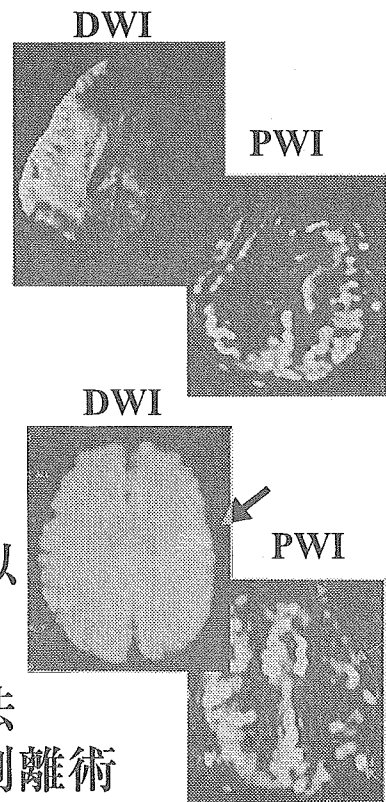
stroke MRI による治療方針の決定
